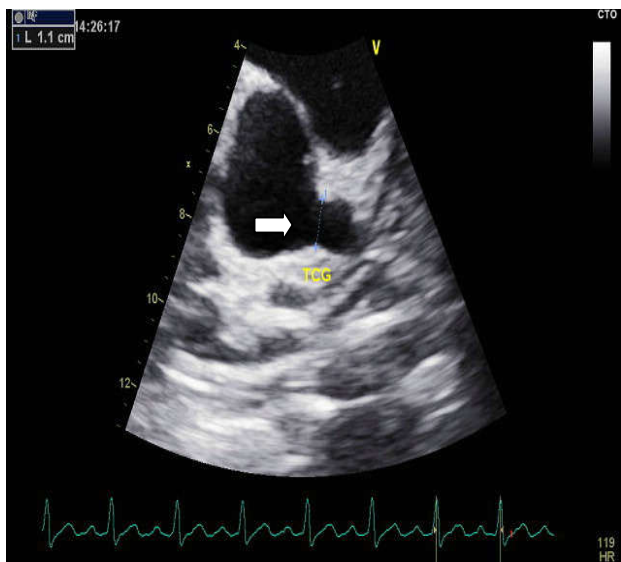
Echocardiography showing a giant aneurism involving the left main coronary artery with a diameter of 11 mm
